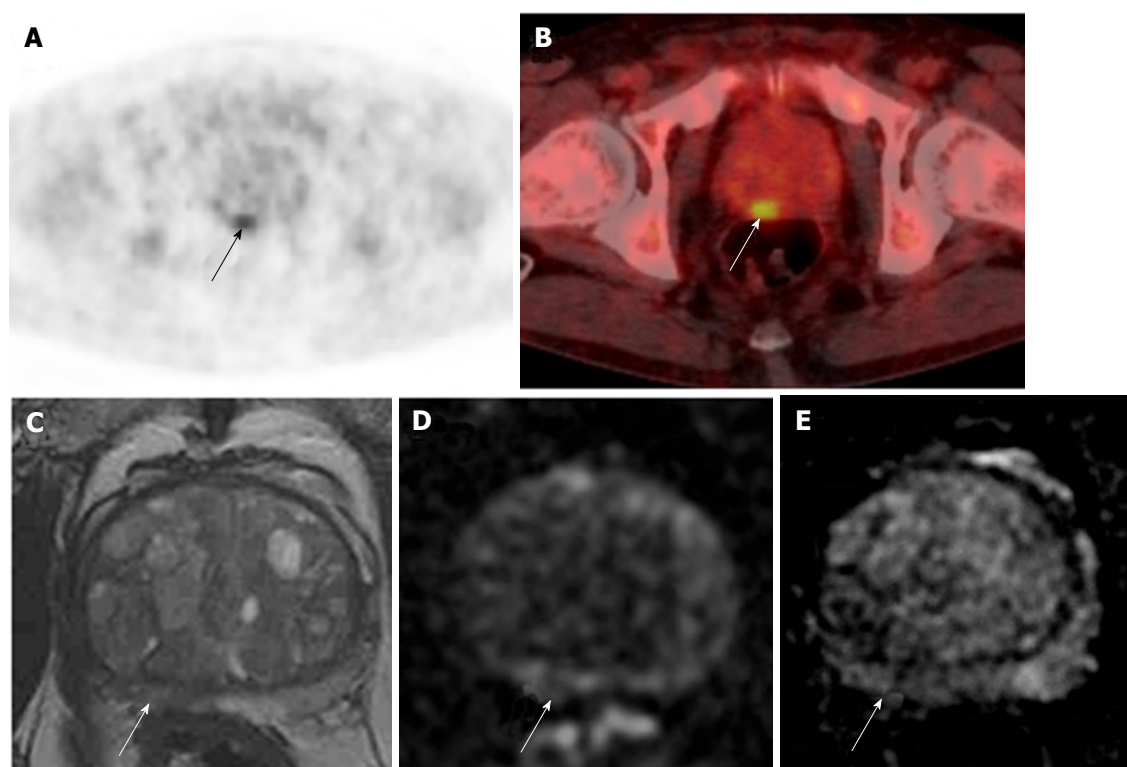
Incidental prostatic ^{18}F -labelled fluorodeoxyglucose uptake in a 67-year-old patient with Stage IV diffuse large B-cell lymphoma. A, B: Focal uptake in the posterior right peripheral zone of the prostate at the level of the mid-gland as demonstrated on PET (A) and fused PET/CT (B); SUV_{max} = 4.5; C-E: Prostate MRI shows non-specific geographical intermediate signal on T2-weighted imaging (C), but with no matching restricted diffusion on b-1400 diffusion-weighted images (D) or ADC maps (E). The MRI findings are low probability for tumour. Subsequent transrectal ultrasound-guided biopsy showed no cancer. PET/CT: Positron emission tomography/computed tomography; MRI: Magnetic resonance imaging; ADC: Apparent diffusion co-efficient.
